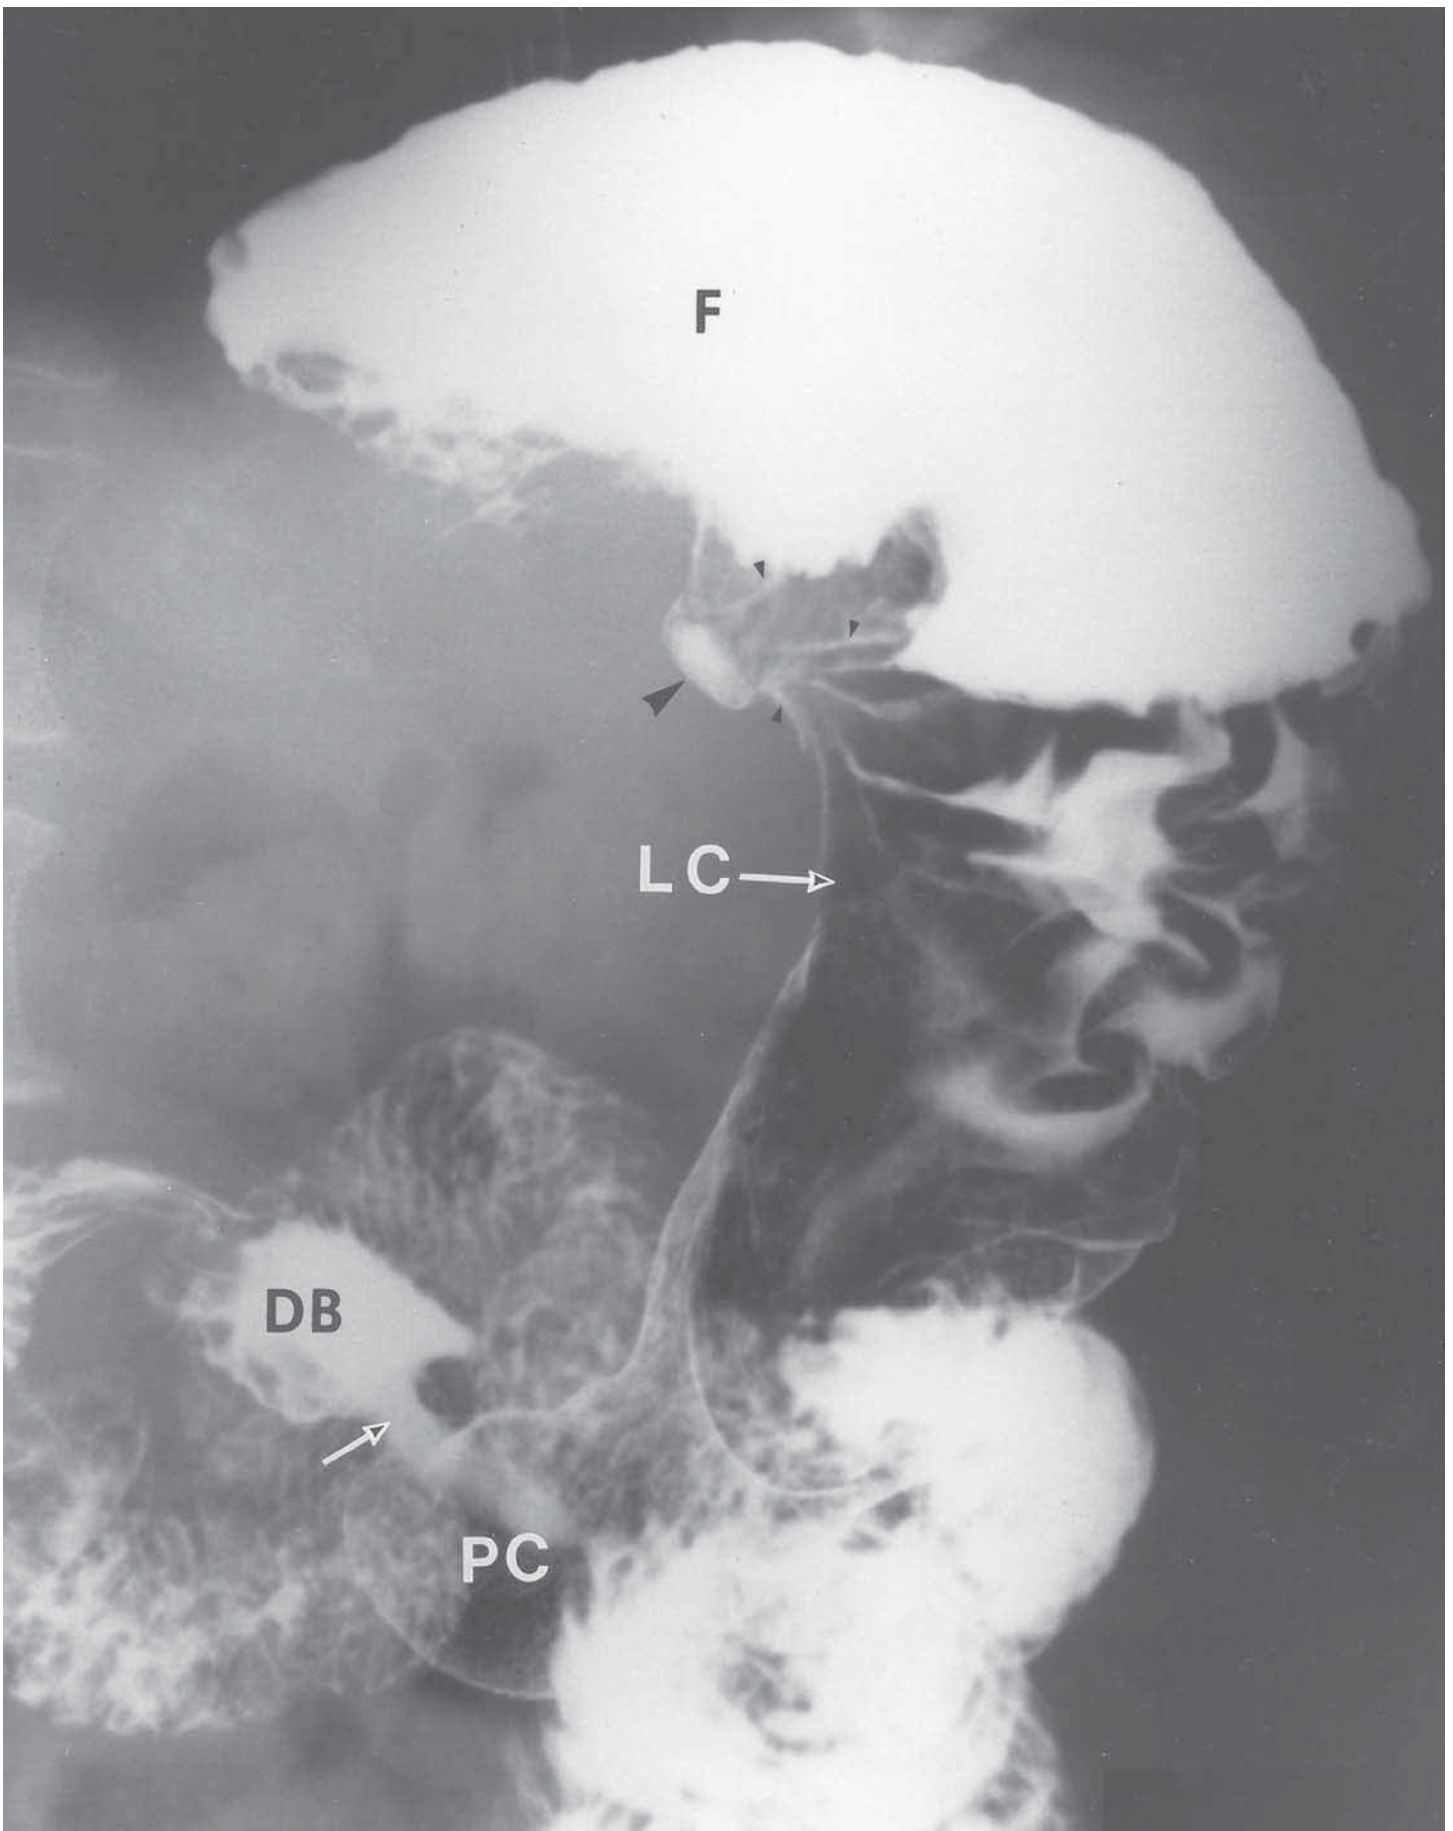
An X-Ray of the Stomach Showing a Small Ulcer
